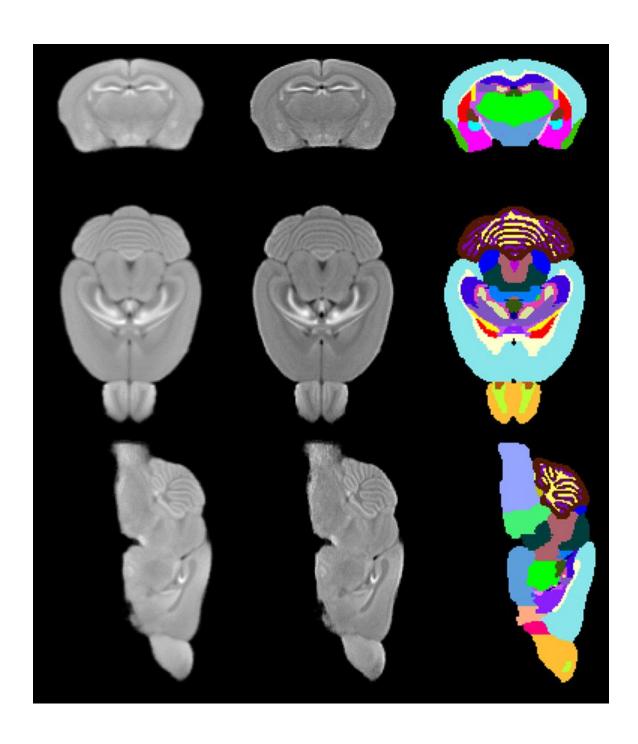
Columns: First: Three orthogonal planes of population average MRI. Second: Edge enhancement of images in first column. Third: Identified structures on these planes:
